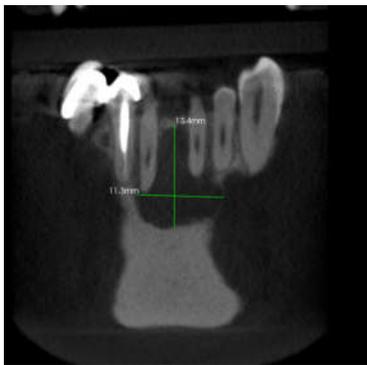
Coronal view cbct
